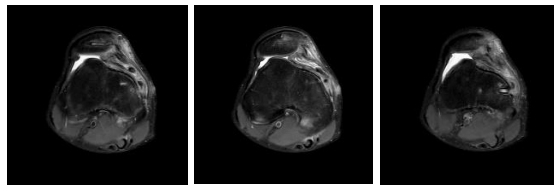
Knee MRI prior to MPFL revision surgery.
